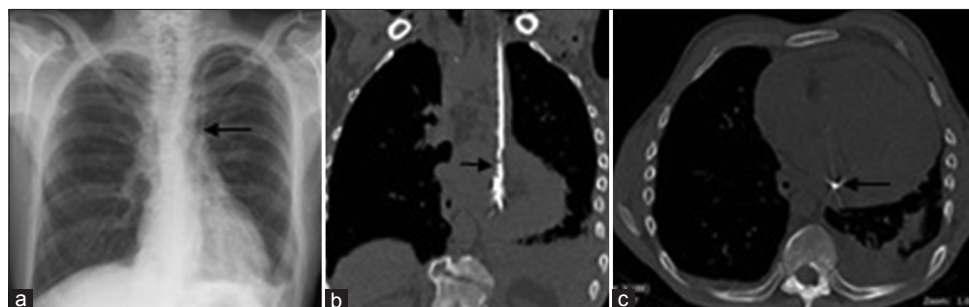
Catheter misplacement to the persistent left-sided SVC.^[32] (a) The chest X-ray demonstrates that dialysis catheter passes down the left side of the mediastinum with pleural effusion and subcutaneous emphysema over the left clavicle (arrow). (b) Computed tomography chest demonstrates the catheter in the persistent left-sided SVC, pericardial and pleural effusion from coronal view (arrow). (c) The arrow indicates the catheter in the persistent left-sided SVC from conventional view. SVC: Superior vena cava.
